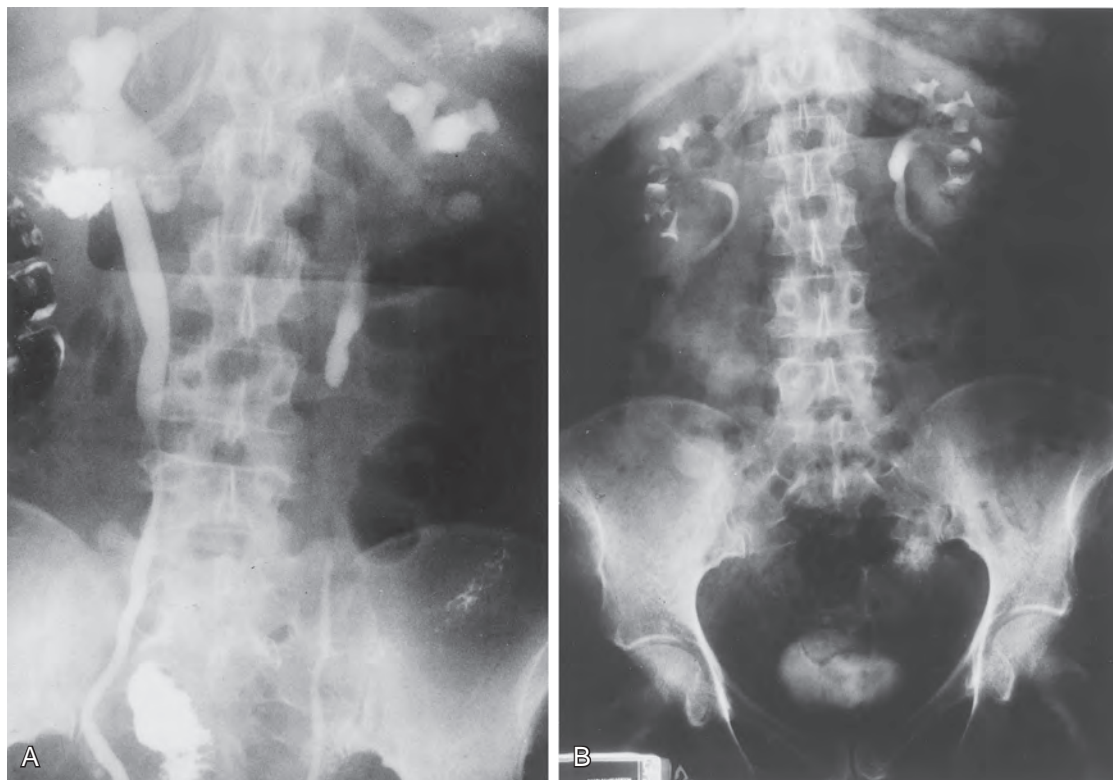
A, Preoperative intravenous contrast-enhanced radiograph of a patient with idiopathic retroperitoneal fibrosis, showing bilateral hydronephrosis with medial deviation of the ureters. B, Postoperative radiograph of the same patient after surgical ureterolysis with intraperitoneal omental wrapping.
